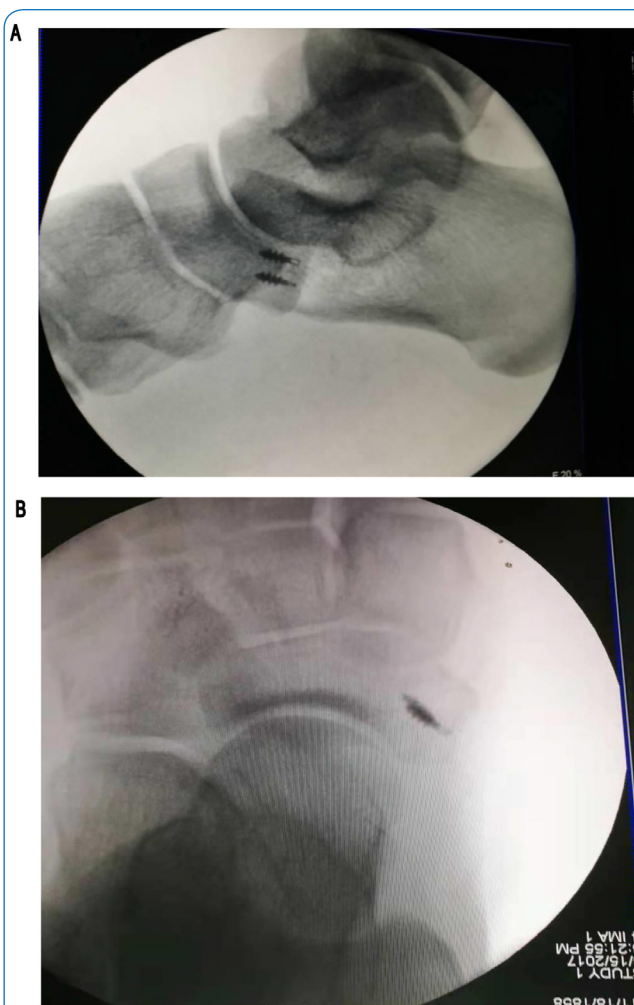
A: Intraoperative X-ray at lateral position, B: Intraoperative X-ray at frontal position.
